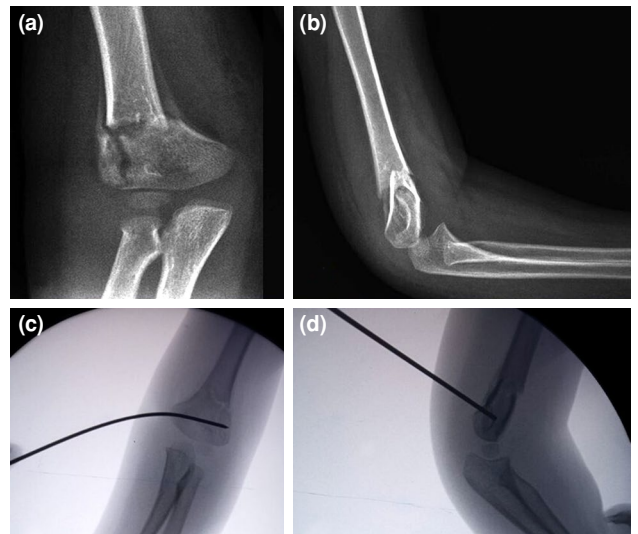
(a) Anteroposterior and (b) lateral radiographs of a Gartland type II supracondylar humerus fracture.
